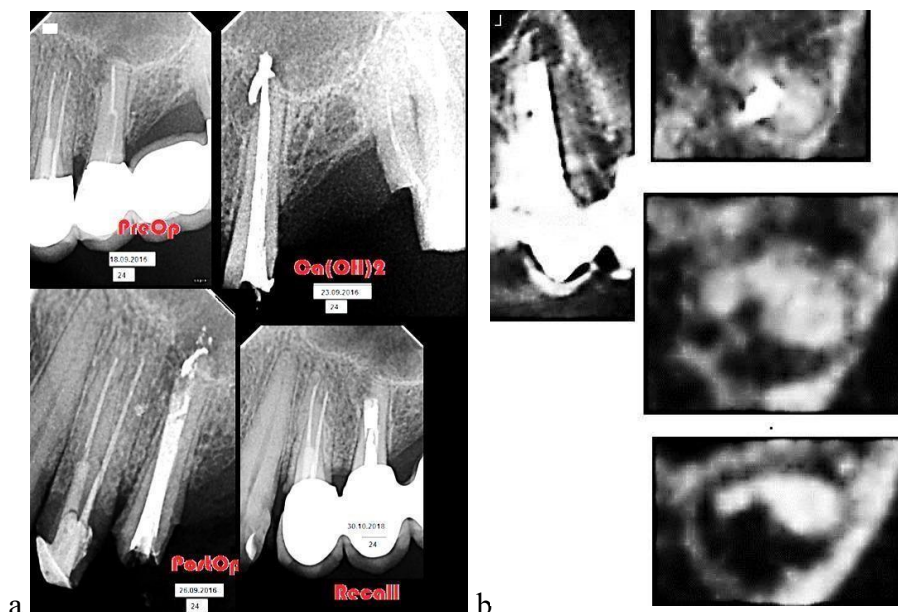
Radiographs of tooth 25: diagnostic, at the time of treatment, and 25 months after completion of treatment (a); diagnostic CBCT of tooth 25 (b)
